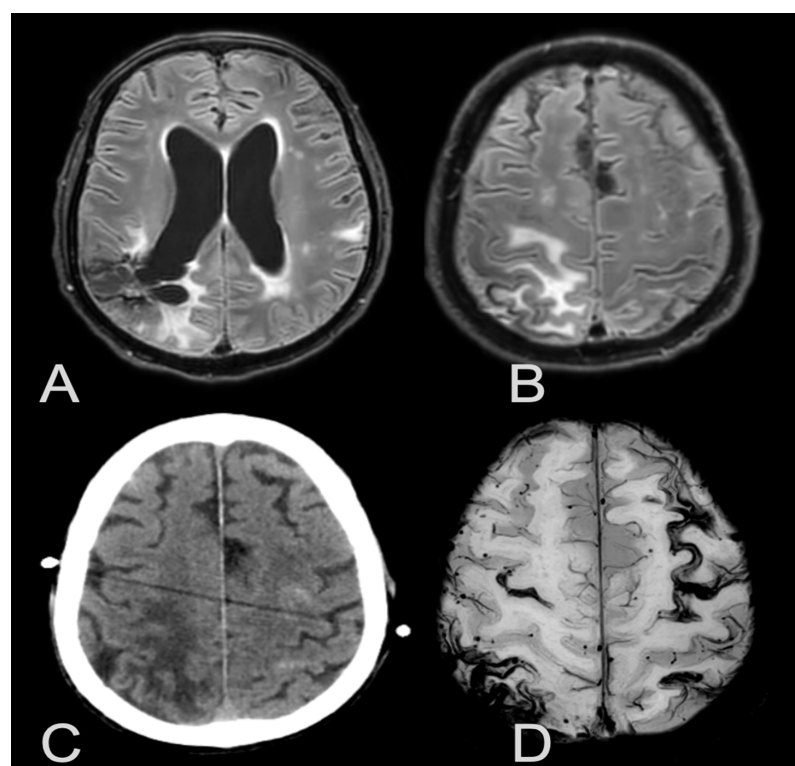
MRI-FLAIR sequence showing ARIA-E in the right and left parietal lobe (A and B); SWI showing diffuse bilateral cortical siderosis with subcortical microbleeds (D). In C, CT shows sulcal subarachnoid haemorrhages.
